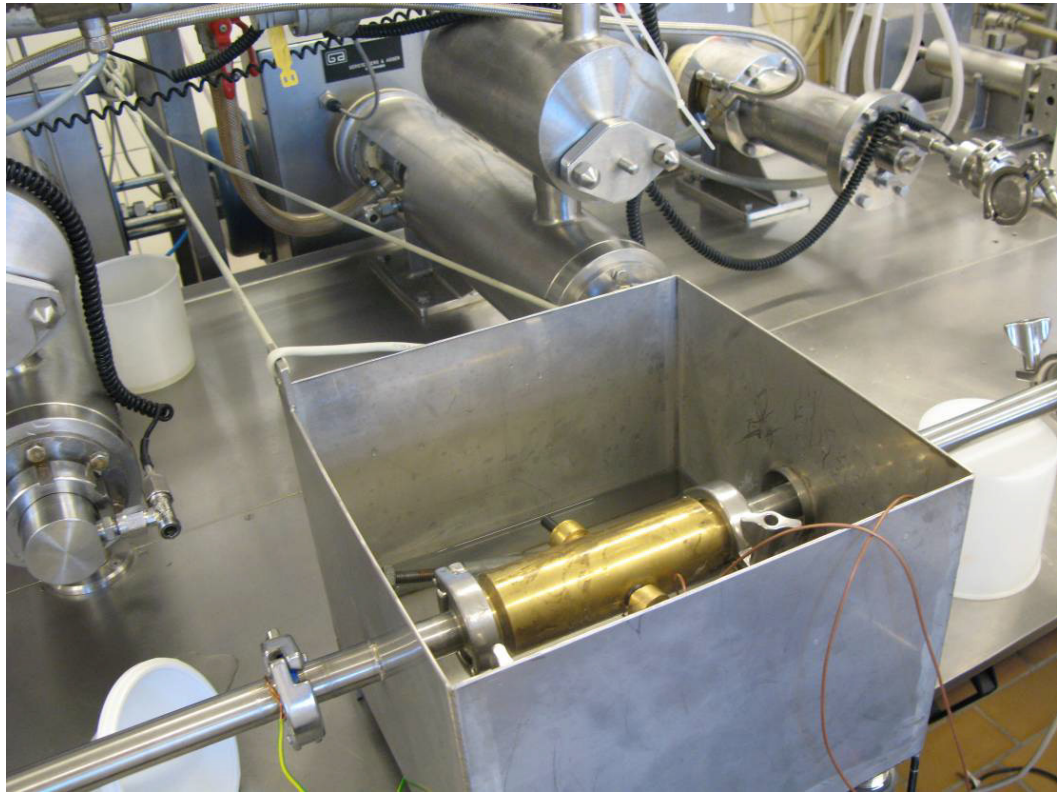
shows close up of UVP-PD in-line measuring section and flow adapter cell fitted with two ultrasound transducers
